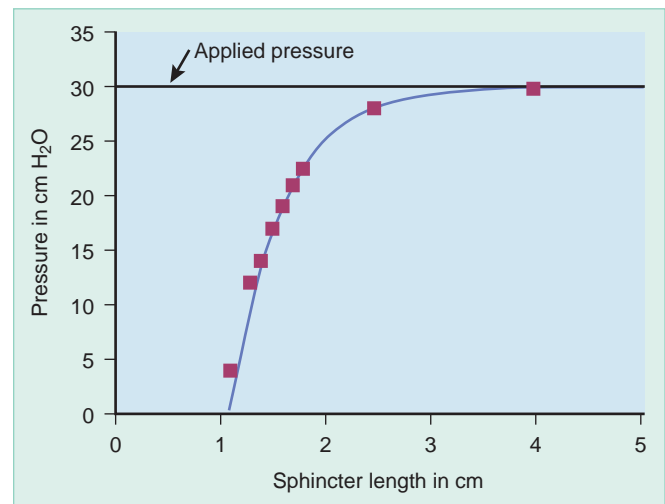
Relationship between resting sphincter pressure and sphincter length when applied pressure or “sphincter squeeze” is kept constant. Analysis was made with a model of the lower esophageal high-pressure zone. Note that as sphincter length decreased, the pressure recorded within the sphincter decreased only slightly until a length of 2 cm was reached, as which point sphincter pressure dropped precipitously and competency of the sphincter was lost. (From Pettersson GB, Bombeck CT, Nyhus LM: The lower esophageal sphincter: Mechanisms of opening and closure. *Surgery* 88:307-314, 1980.)
